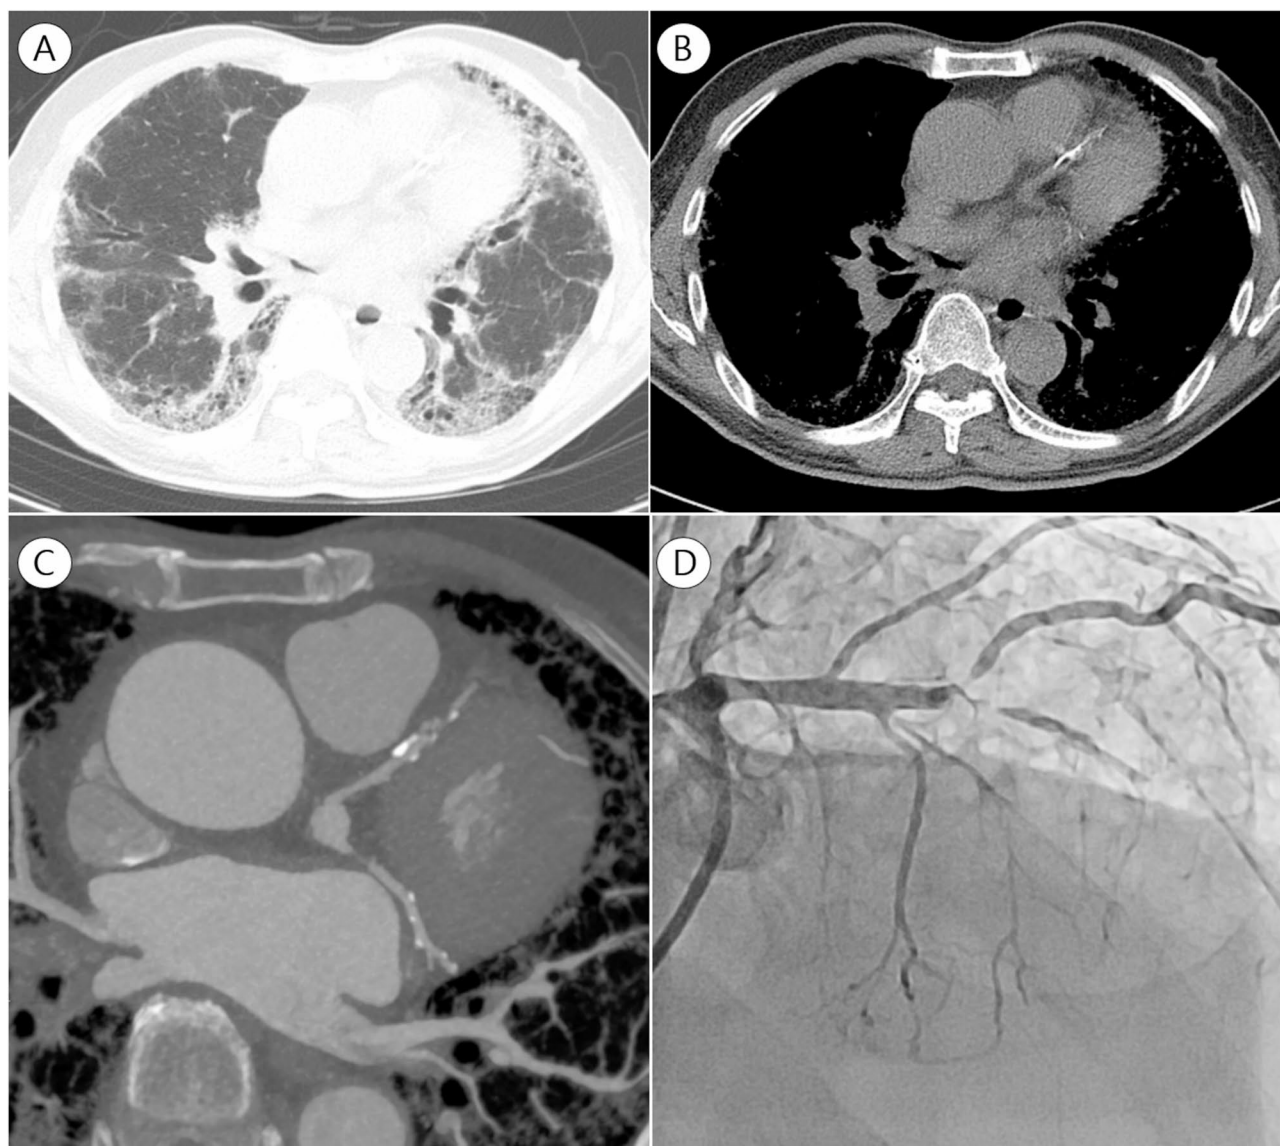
Representative images of patients with significant CAD. (a) High-resolution computed tomography (HRCT) of the lungs showing ILD with a typical pattern of reticulation and honeycombing (b) Mediastinal view of HRCT highlighting cardiac structures, showing coronary artery calcification in the left anterior descending (LAD) artery. (c) CCTA showing significant stenosis of the LAD artery, (d) Coronary angiogram providing a detailed view of the LAD artery leading to revascularization
